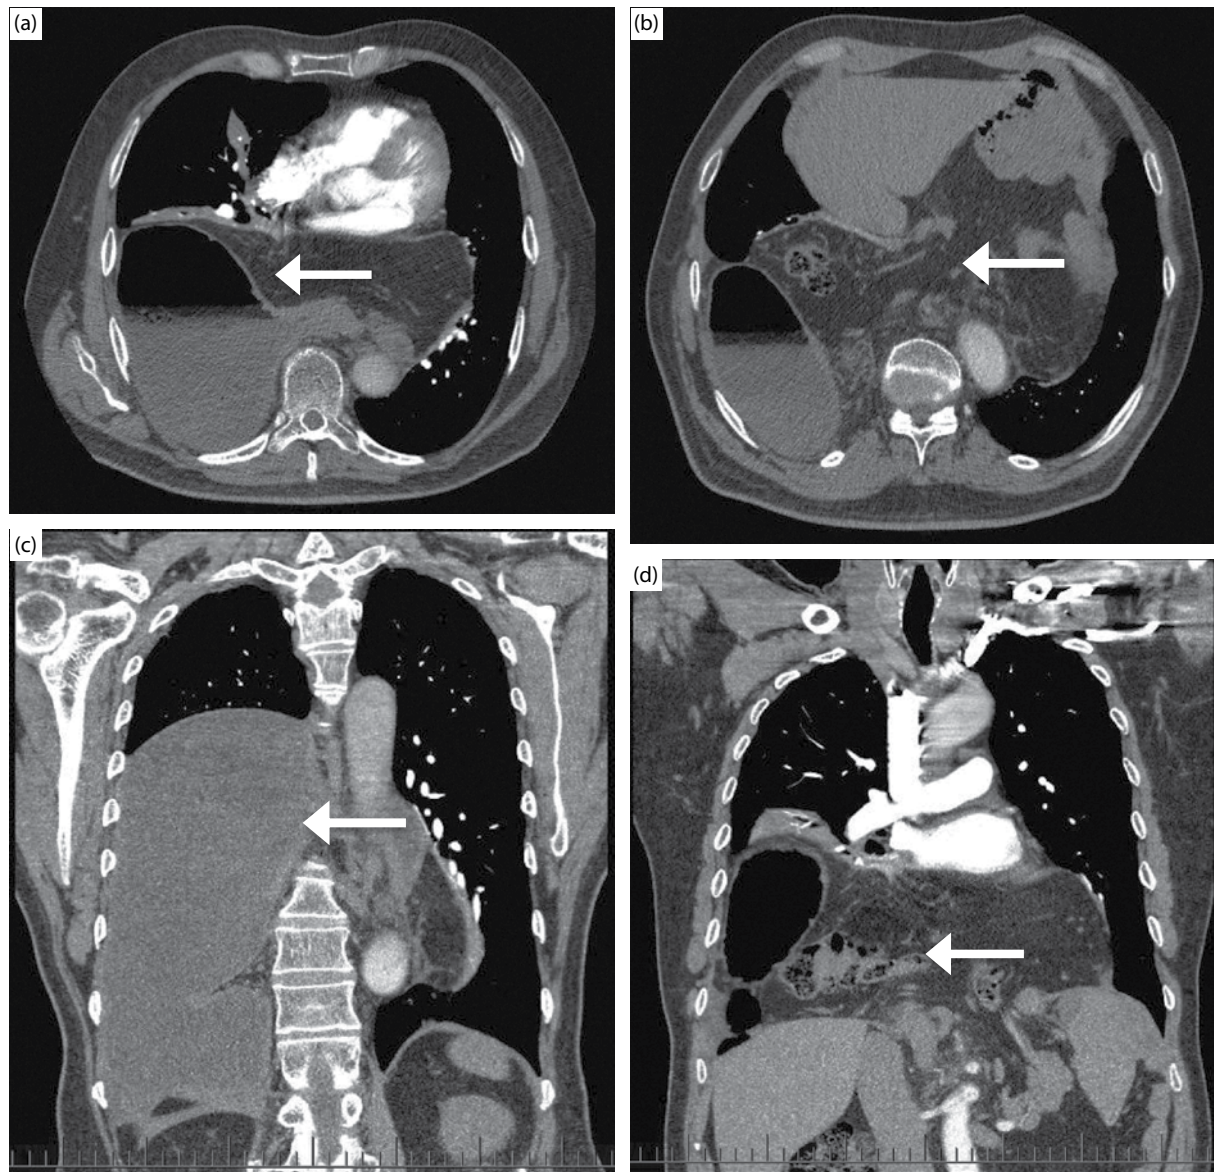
Chest computed tomography images of acute paraesophageal hernia recurrence with gastric volvulus and obstruction. This patient presented with shortness of breath and dysphagia following an episode of vomiting 2 weeks after paraesophageal hernia repair with Nissen fundoplication. Axial images demonstrating (a) intrathoracic stomach with air fluid level and (b) tight diaphragmatic defect (arrows). Coronal images showing (c) dilated and fluid-filled obstructed stomach and (d) intrathoracic transverse colon (arrows).
